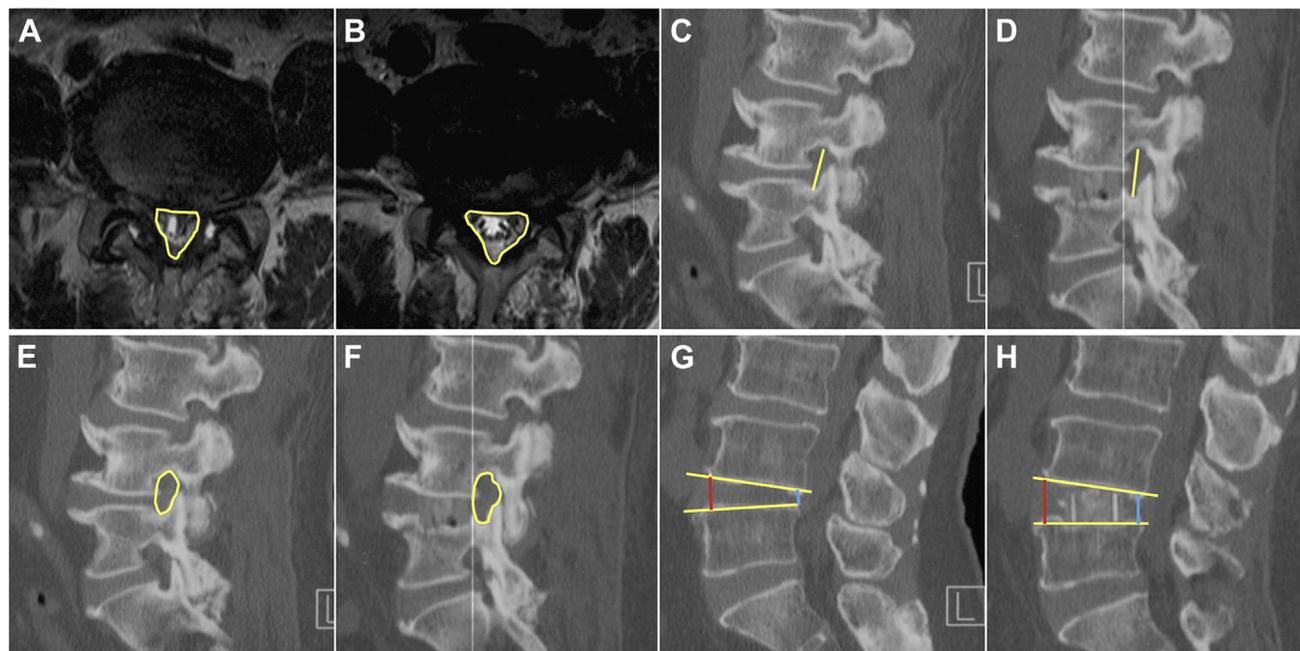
Measurement of cross-sectional area (CSA), disk height (DH), cross-sectional height (CSH), and cross-sectional areas of the intervertebral foramina (CSAF). Measurements of CSA, DH, CSH, and CSAF in the Picture Archiving Communication System (PACS) before the operation and at the last follow-up. (A and B) CSA was measured in the axial sections of T2-weighted imaging. The central canal (including the thecal sac and epidural fat) was outlined in PACS to get the area of CSA. (C and D) CSH
